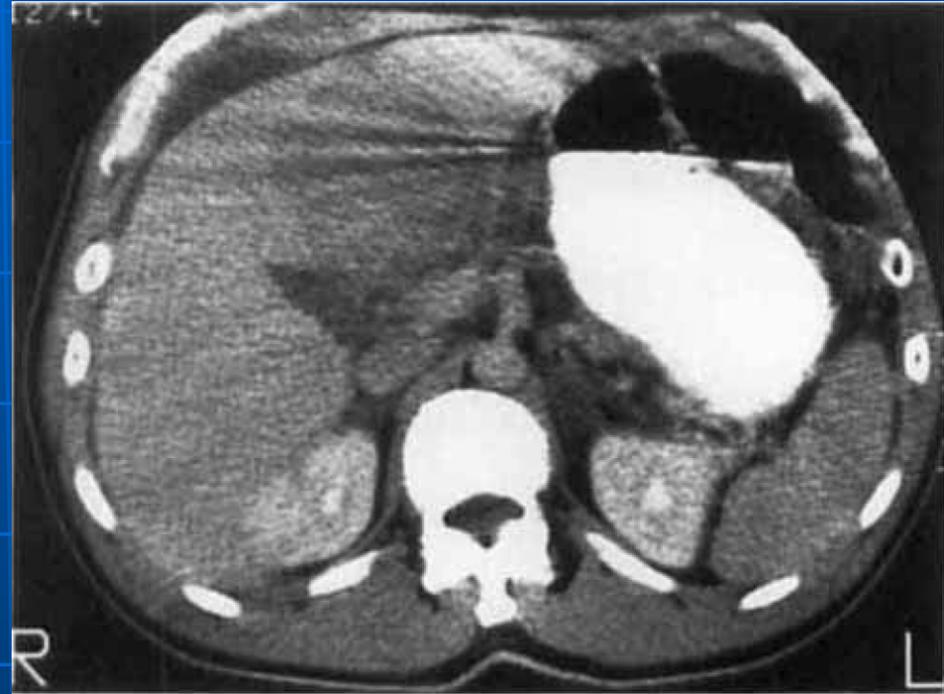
Computed tomography scan of the abdomen 1 year after initial surgery showing multiple intraperitoneal masses among the loops of the bowel, a 7-cm density in the left lobe of the liver, and ascites.
